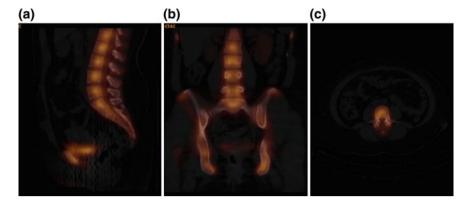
SPECT/CT images of the spine. Sagittal (a), coronal (b), and axial (c) plane fused CT (*grayscale*) and SPECT (color over-projection) images from a SPECT/CT study of the spine obtained for assessment of possible metastatic bone lesions in this patient with a history of metastatic cancer and back pain (no metastatic lesions are apparent on these images)
